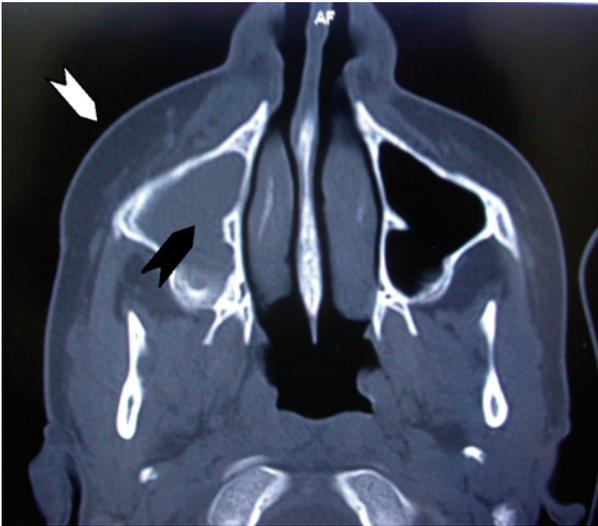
Axial CT of case 1 showing obliteration of the right maxillary sinus (black arrowhead) and soft tissue swelling over the right infra-orbital region (white arrowhead)
